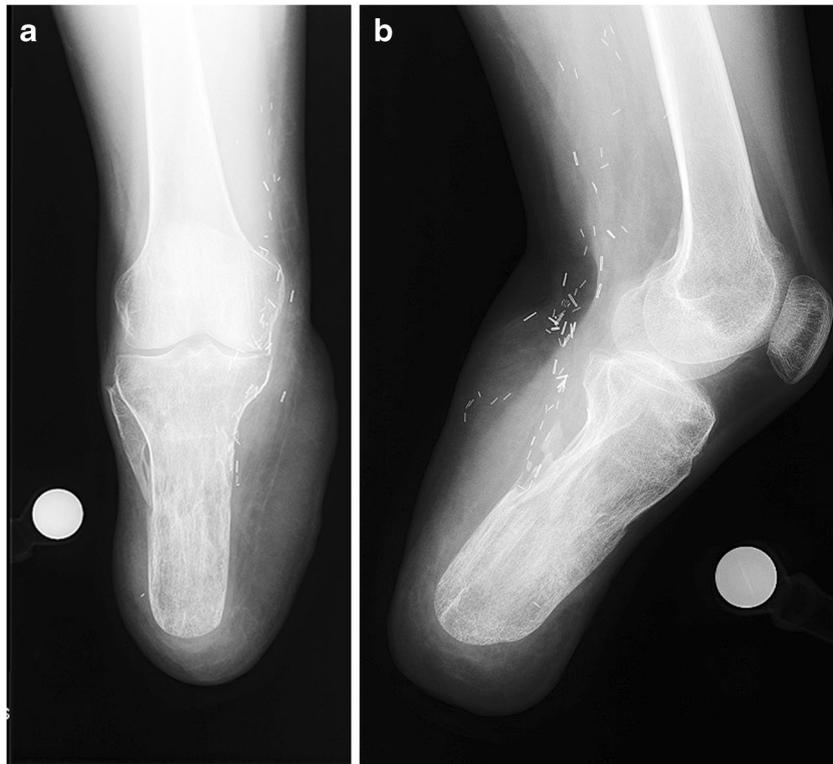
AP and lateral radiographs 2 years after surgery. Note the well-healed bone 15 cm in length without deformity.
